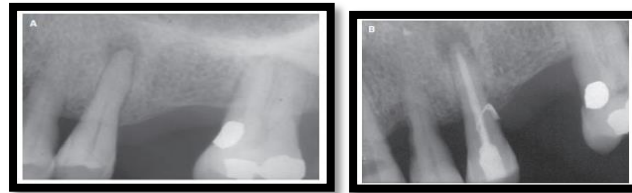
Maxillary premolars with primary periodontal disease and secondary endodontic treatment. (A) X-rays showing radiation permeability and bone loss around the apex of one-third of the root of unity. The crown was intact, but the pulp susceptibility test was negative. (B) Radiographs taken immediately after root canal treatment show a sealer of the lateral root canal exposed due to bone loss.
